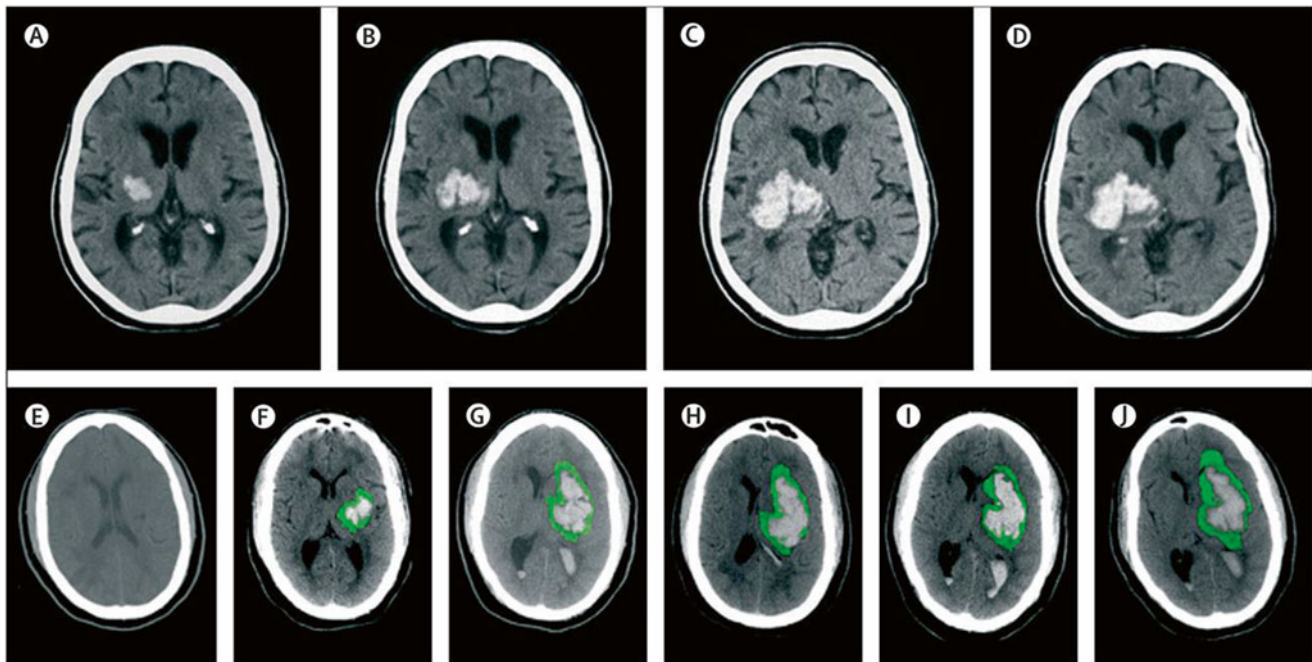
Progression of hematoma and edema on computed tomography (CT): hyperacute expansion of hematoma in a patient with intracerebral hemorrhage on serial CT scans. Small hematoma detected in the basal ganglia and thalamus (a). Expansion of the hematoma after 151 min (b). Continued progression of the hematoma after another 82 min (c). Stabilization of the hematoma after another 76 min (d). Bottom: progression of hematoma and perihematomal edema in a patient with intracerebral hemorrhage on serial CT scans. The first scan (e) was
